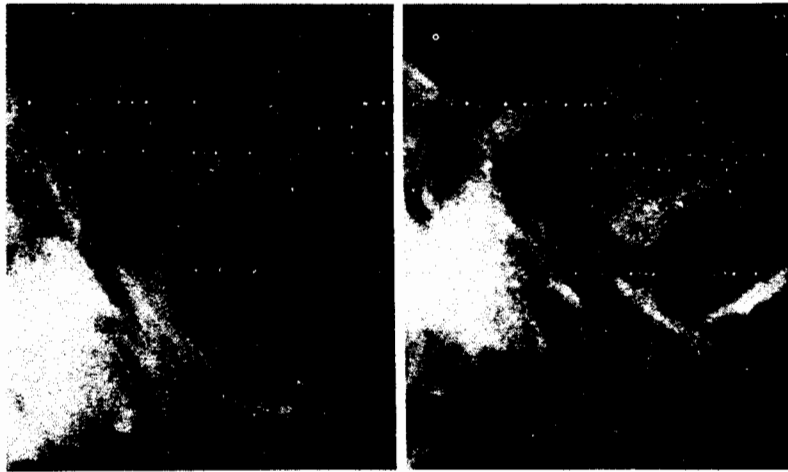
Preoperative roentgenogram of patient's normal right mandibular joint.
